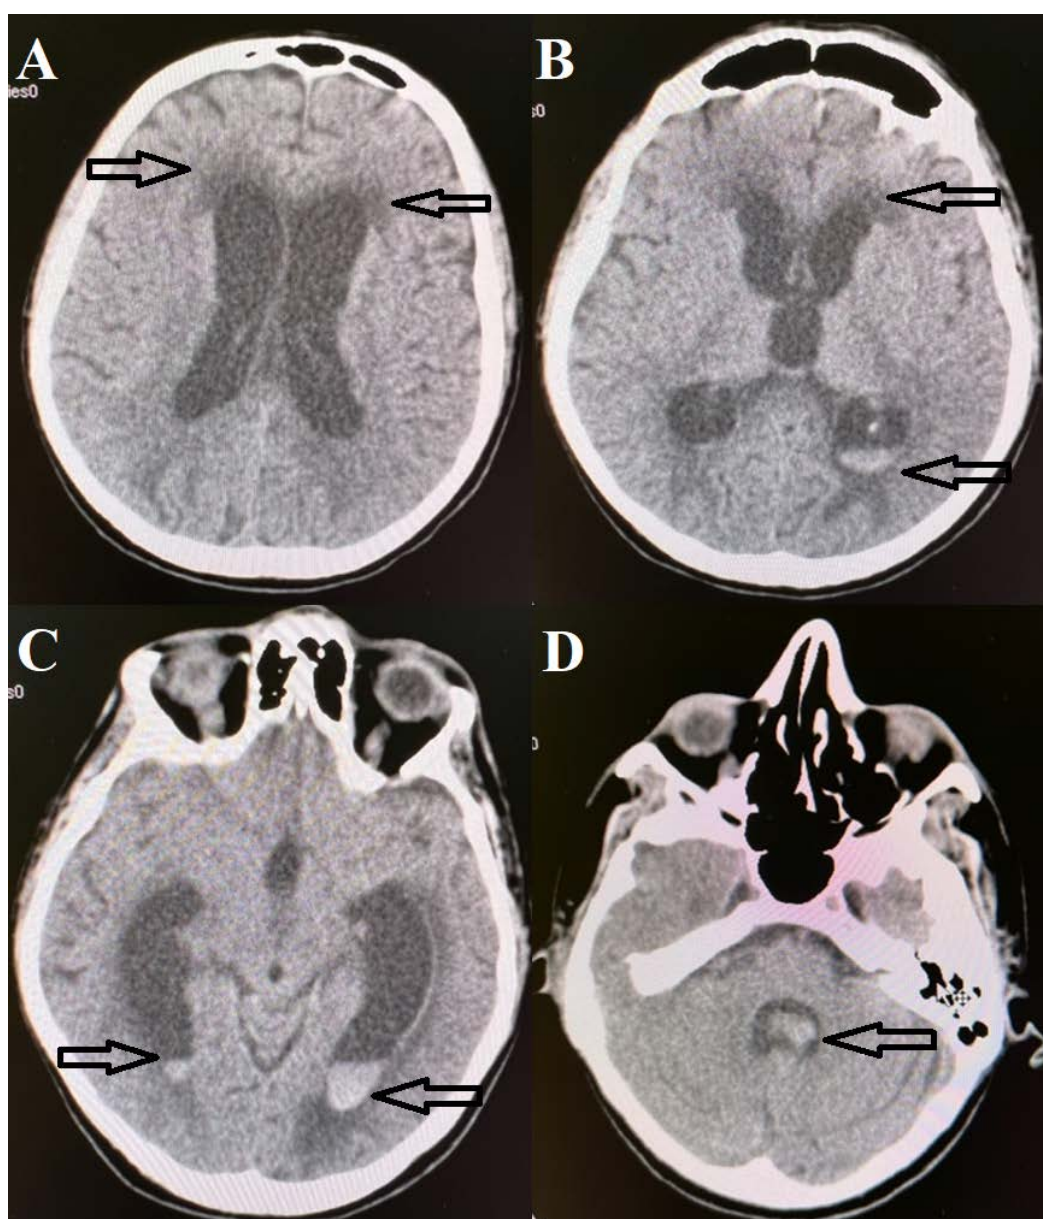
Non-contrast axial computed tomography findings indicate the existence of hydrocephalus with periventricular lucency (A, B, C), intraventricular hemorrhage (IVH) in the occipital horns of the lateral ventricles (B, C), and IVH in the fourth (D) ventricle (arrows).
